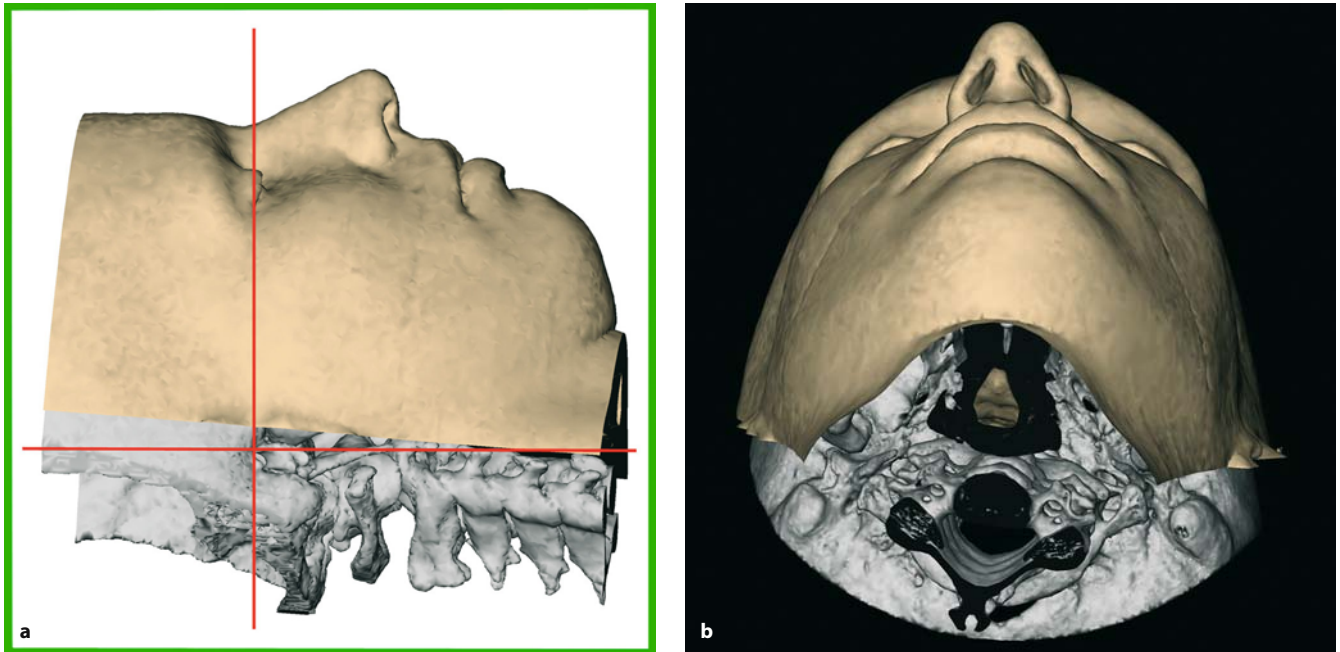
a,b. Base view (patient K.C.). In order to compute the virtual base view X-ray, the skull is virtually positioned in the frontal view and posteriorly inclined until the cantho-meatal or trago-canthal line is perpendicular to the vertical plane
